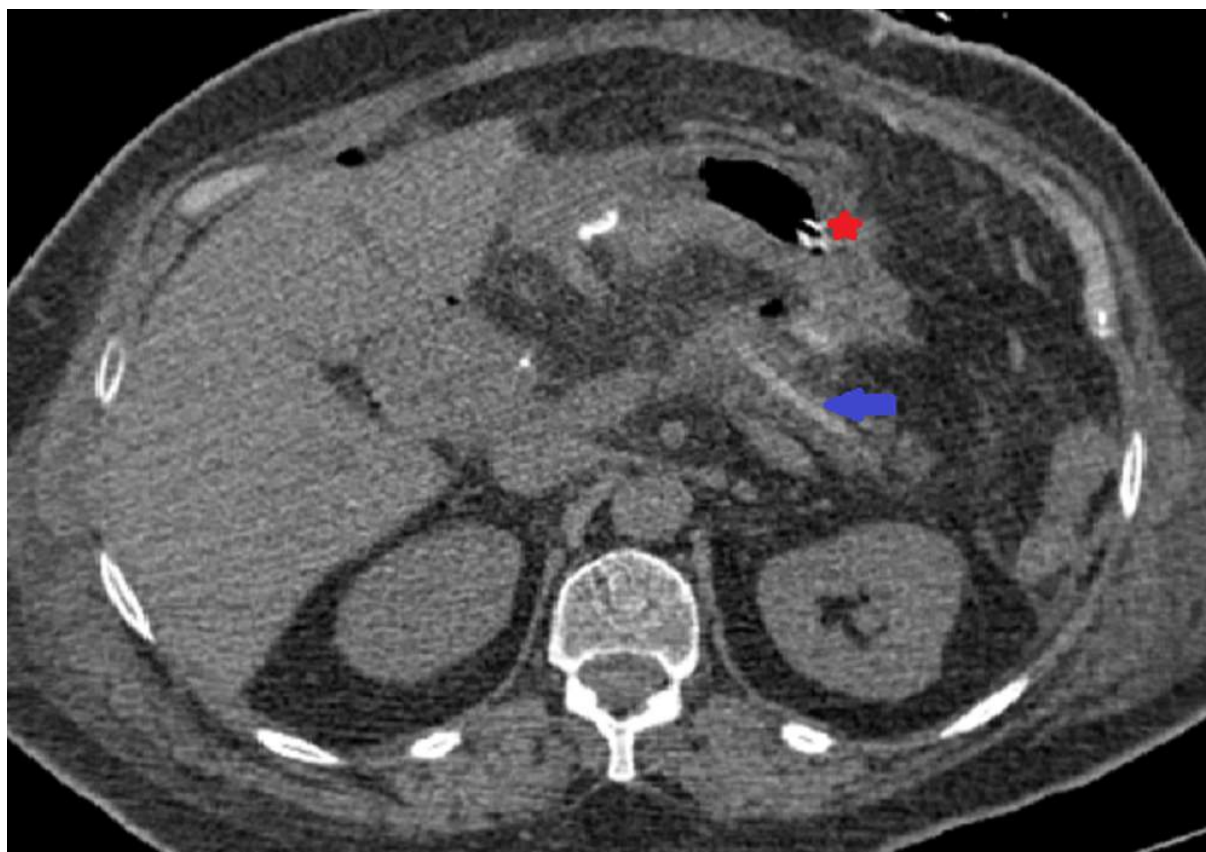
Non-injected abdominal and pelvic CT showing an internal stent (blue arrow) of the residual pancreas postoperatively. Note the presence of a nasogastric tube (red star)
